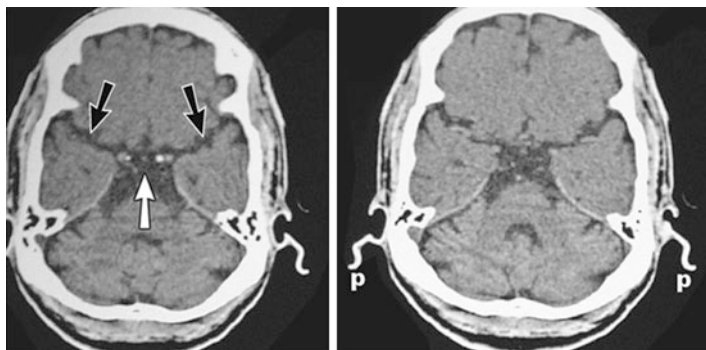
Right and left *sylvian fissures* (black arrows) meeting at the *suprasellar cistern*. You can trace these narrow CSF pathways in each successive slice until it breaks up into small channels. It is present in every brain CT scan but not always visible due to variations in their size but you must look here for evidence of CSF distortion or subarachnoid hemorrhage! Outside the skull you can see the cartilage of the pinna (p), another important point of reference as you navigate the CT images
